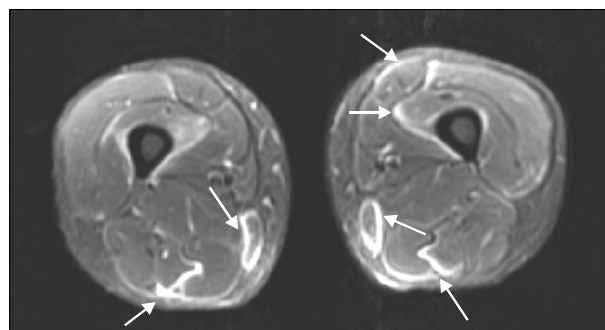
The signal intensity at STIR magnetic resonance imaging (MRI) of transaxial section. No signal intensity (arrowhead on Biceps femoris), subtle signal intensity (short narrow arrow on Semimembranosus) were represented for score 0 and 1, respectively. Focal signal intensity (long narrow arrow on Vastus intermedialis) in each muscle which was affected less than 50% of area was represented for score 2. Diffuse signal intensity (wide arrow on Gracilis) was represented for score 3.
